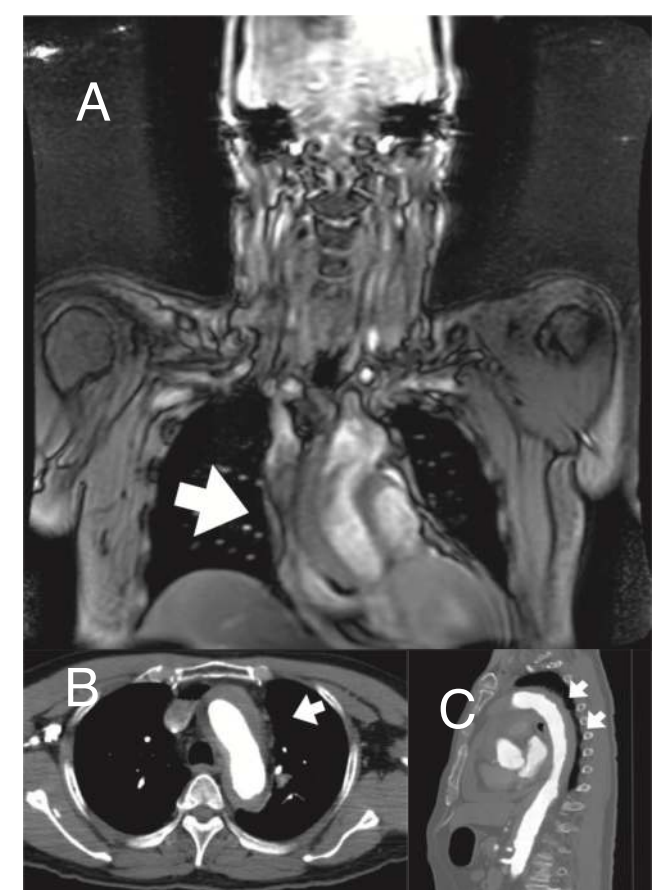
A representative case with cerebral ischemia caused by aortic dissection which was diagnosed by chest MRA (A). B, C: Enhanced chest CT.
